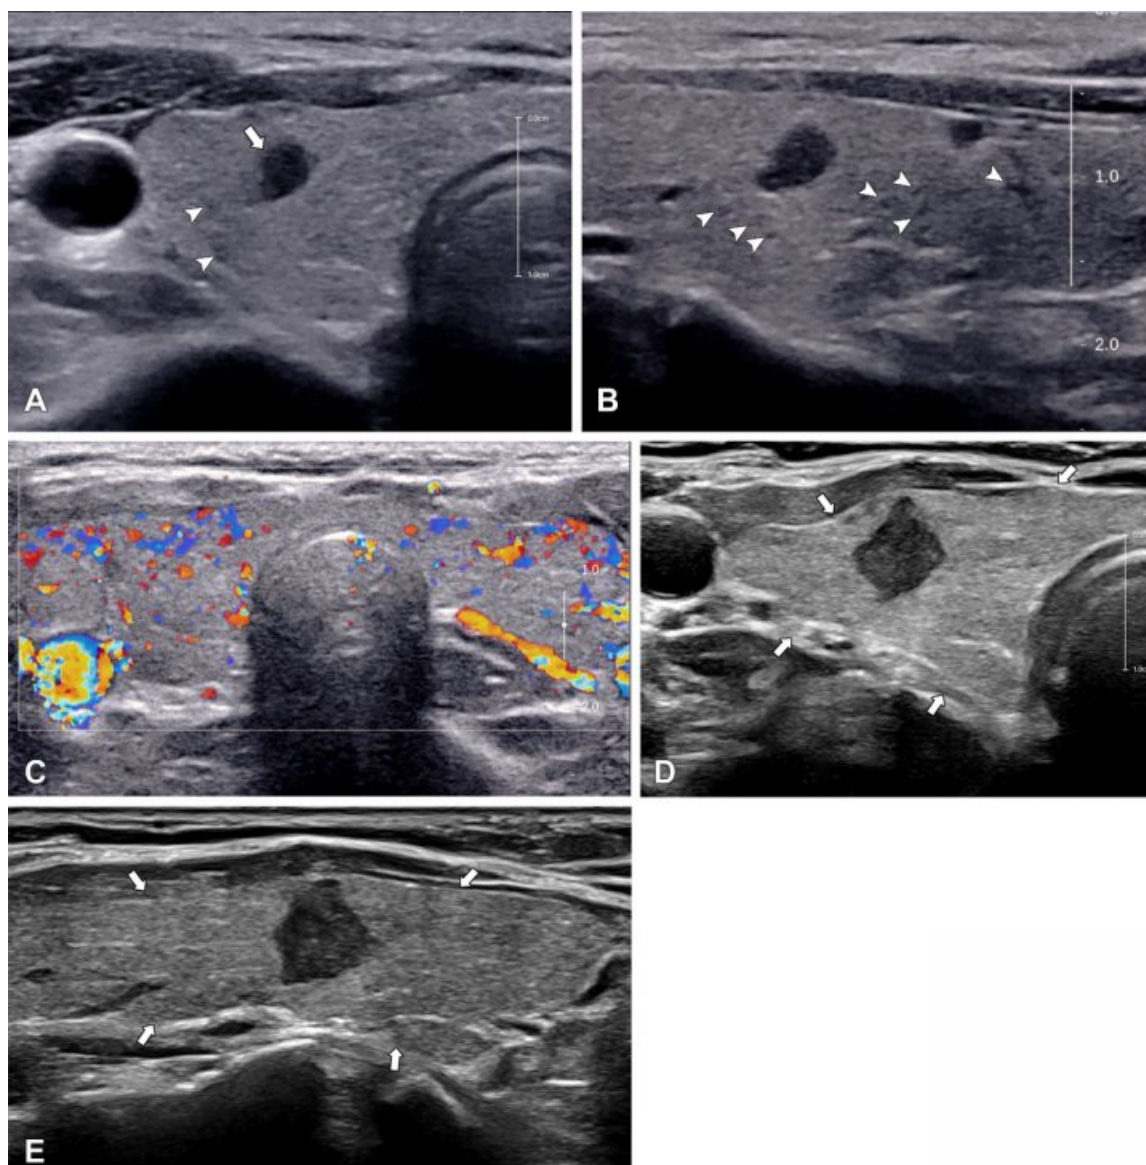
Enlargement of a tumor in the presence of diffuse thyroid disease in a 47-year-old female participant with papillary thyroid microcarcinoma (PTMC). (A–C) Baseline US images. (A) Transverse and (B) longitudinal images of the right thyroid gland show a solid hypoechoic nodule (arrow in A) with a maximal diameter of 4 mm. Thyroid parenchyma shows a coarse micronodular echotexture pattern (arrowheads) and was classified as positive for diffuse thyroid disease. (C) Color Doppler image shows diffuse increased vascularity in the thyroid gland. (D, E) US images at 18-month follow-up. (D) Transverse and (E) longitudinal US images demonstrate tumor enlargement to 8 mm. Background thyroid parenchyma shows mild diffuse hypoechogenicity involving whole thyroid gland, with lobulated contour (arrows). No suspicious lymph nodes were observed at US or CT. Subsequent lobectomy and ipsilateral central neck dissection showed PTMC with lymphocytic thyroiditis. Two metastatic lymph nodes were diagnosed out of five dissected lymph nodes.
